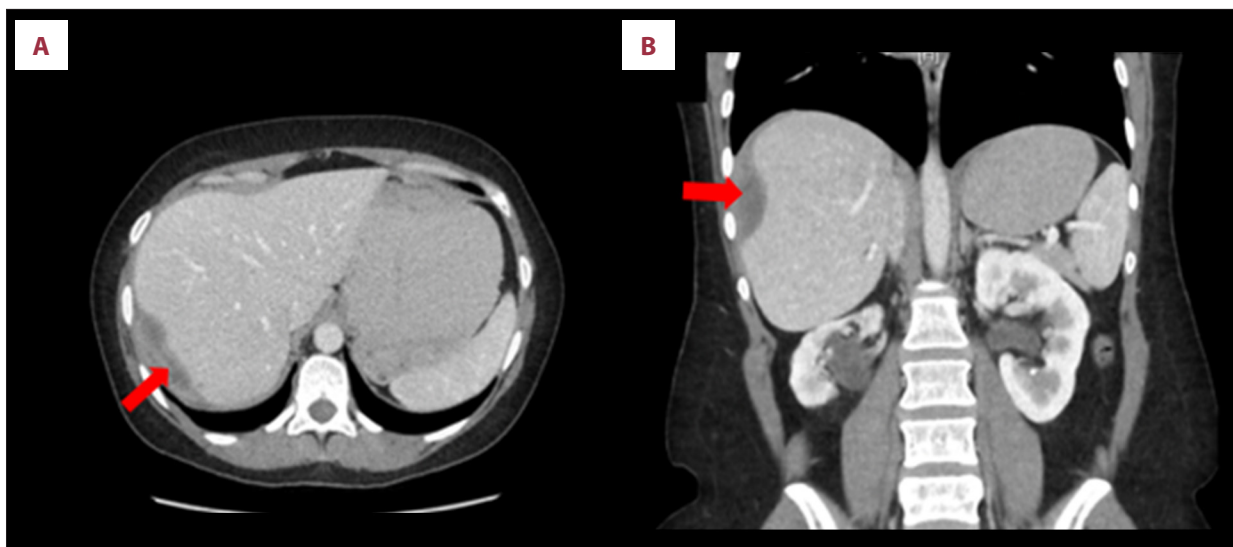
Abdomen-pelvis computed tomography (CT) scan without contrast. Axial plane (A); coronal plane (B). Significant radiological improvement of hepatic subcapsular hematoma, compared with previous CT scan results; dimensions 77.6CC×45AP×16T. No free fluid.
